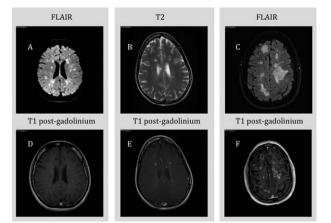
Refer to subjects from Table 2. (A) Fast fluidattenuated inversion recovery (FLAIR) image and (D) T1weighted magnetic resonance imaging (MRI) with gadolinium in Patient #5 with 16 gadolinium-enhancing lesions. (B) T2-weighted MRI and (E) T1-weighted MRI with gadolinium in Patient #3 with 10 gadolinium-enhancing lesions. (C) FLAIR image and (F) T1-weighted MRI with gadolinium in Patient #1 with 40 gadolinium-enhancing lesions.
